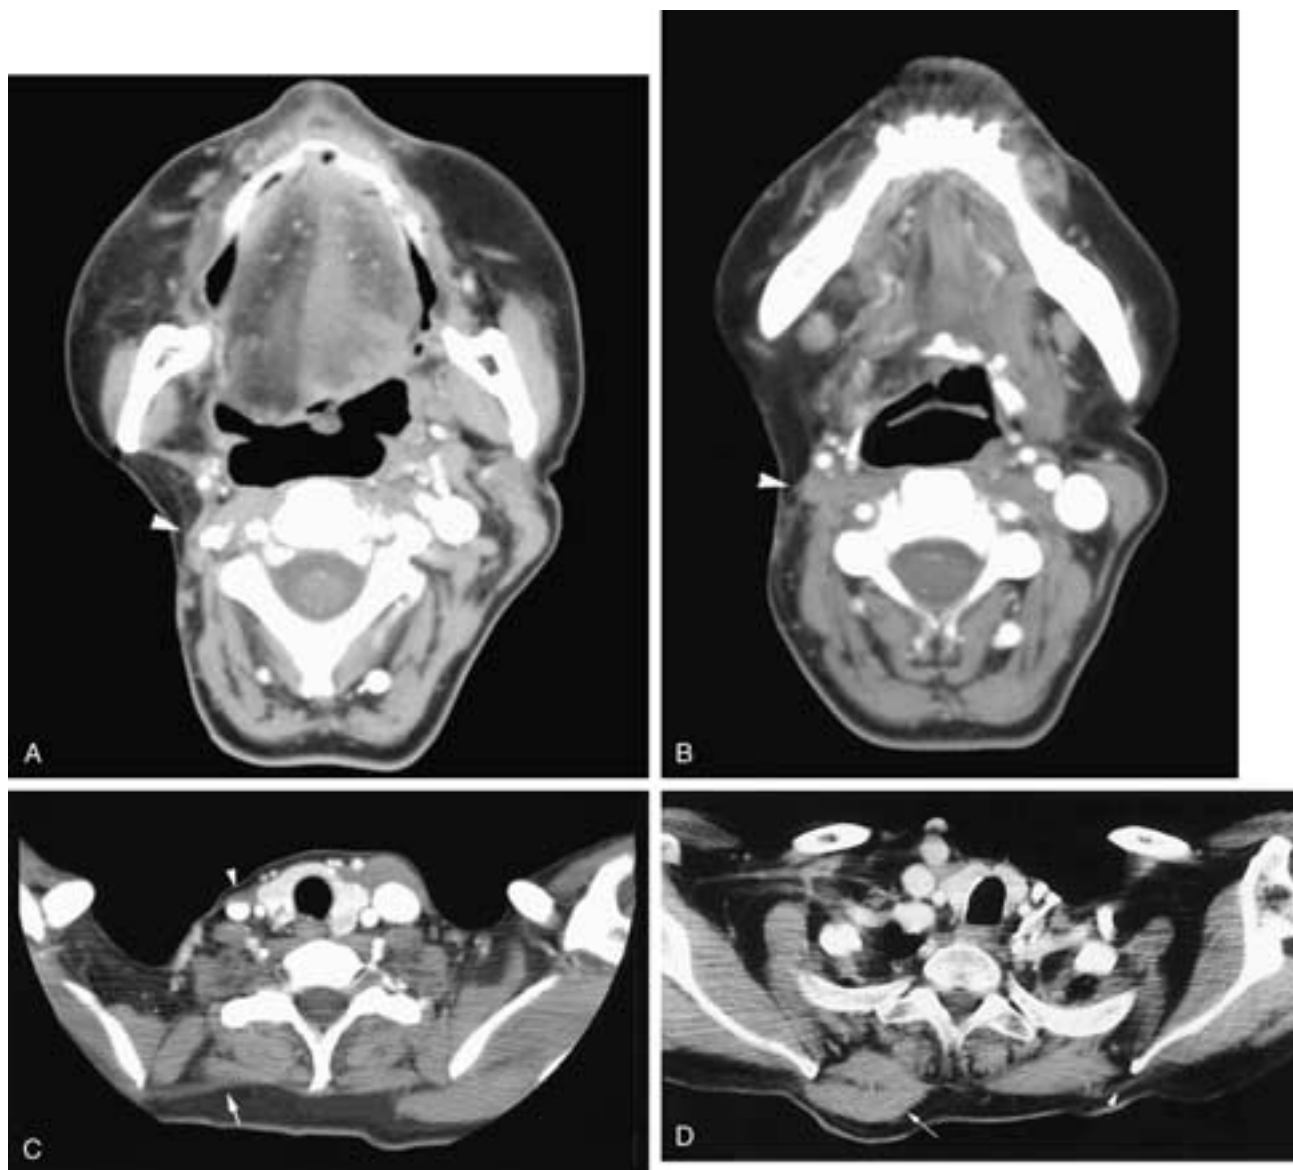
Serial axial contrast-enhanced CT scans from cranial (A) to caudal (D) on a patient who has had skull base surgery with damage to his right cranial nerves V, VII, and IX to XII. In A, there is marked atrophy of the right sternocleidomastoid muscle (*arrowhead*) and fatty replacement of the right-sided tongue muscles. As a result, the right base of the tongue prolapses back farther than the left side, possibly suggesting the presence of a mass on the right. The right internal pterygoid and masseter muscles are also smaller than their left-sided counterparts. In B, there is atrophy of the right sternocleidomastoid (*arrowhead*) and trapezius muscles. There also is atrophy of the muscles in the right side of the floor of the mouth. In C, the marked atrophy of the right sternocleidomastoid (*arrowhead*) and trapezius (*arrow*) muscles is clearly evident. In D, an axial contrast-enhanced CT scan through the lower neck of a different patient who has had a left radical neck dissection shows denervation atrophy of the left trapezius muscle (*arrowhead*). The right trapezius is normal, but its bulk could be mistaken for a mass (*arrow*).
